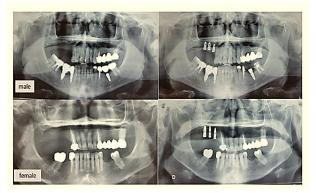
Orthopantomographic images of patients treated with maxillary sinus lifting surgery and with non-autogenous
